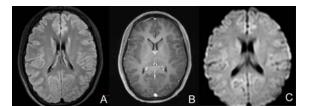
Follow-up MRI at 5 months after the attack: (A) FLAIR, (B) Gd-T1wi, (C) DWI show no residual abnormal SI or enhancement
